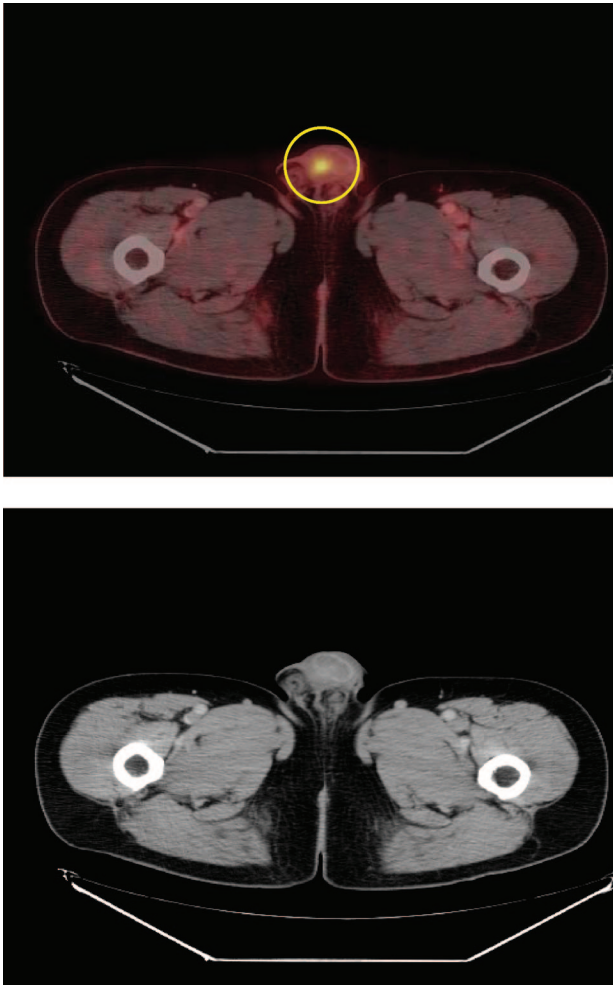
A 59-year-old man with squamous cell carcinoma in inguinal lymph nodes. The primary tumor site in the urethra was only visible on the combined positron emission tomography/computed tomography scan but not with computed tomography alone.
